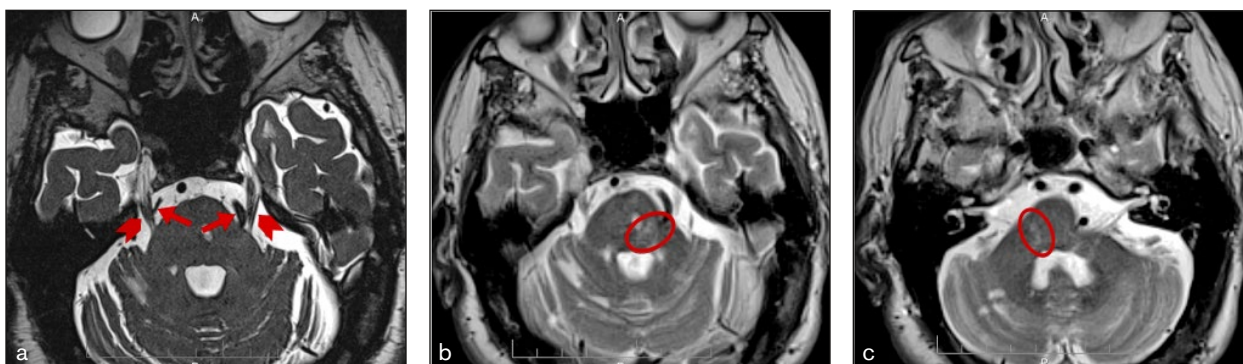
The MRI 3D constructive interference in steady state (3D-CISS) image (a) shows the trigeminal nerve course (marked by arrowheads) and an arterial loop consisting of the superior cerebellar artery on the right side and the vertebral artery on the left side (arrows). The MRI TSE T2-weighted images show the demyelinating plaque (circle) involving (b) the trigeminal root entry zone and (c) the caudal and posterior pontine portion.
